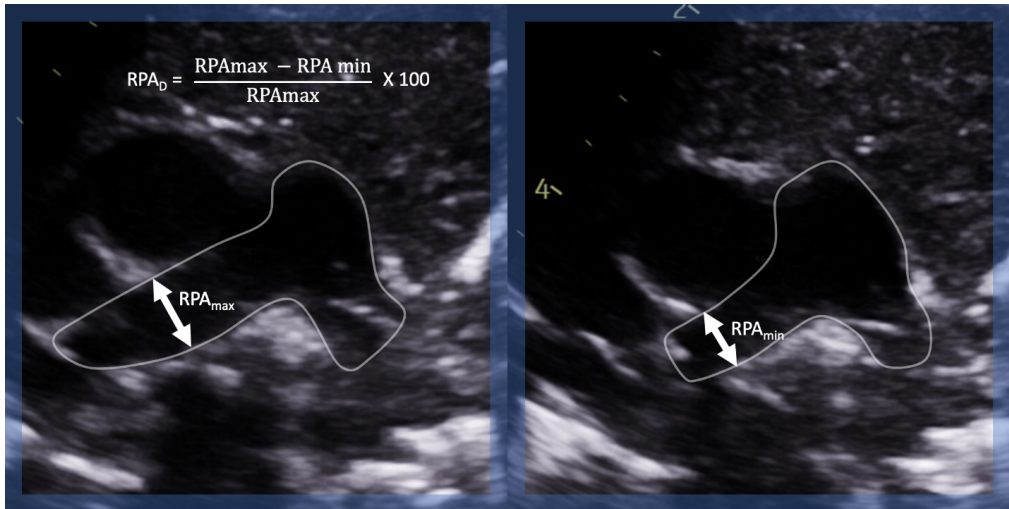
Right pulmonary artery distensibility index (RPA_D) measurement in a parasternal short axis view of the pulmonary arteries.
